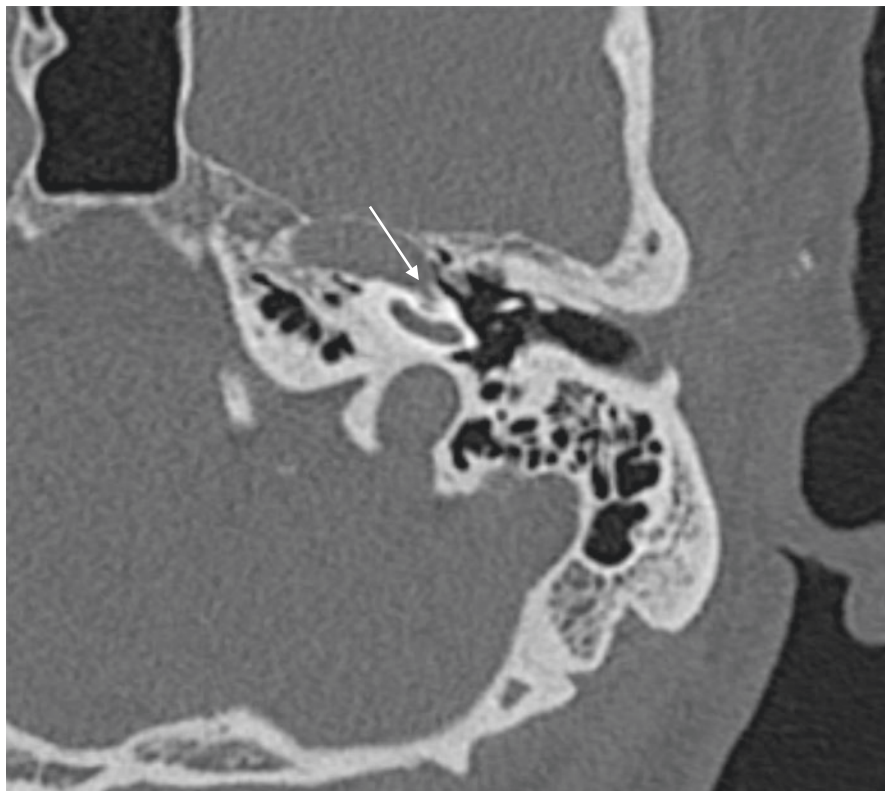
Axial CT scan demonstrating a bony defect along the apical turn of the left cochlea (arrow), creating an anomalous communication with the adjacent left carotid canal
